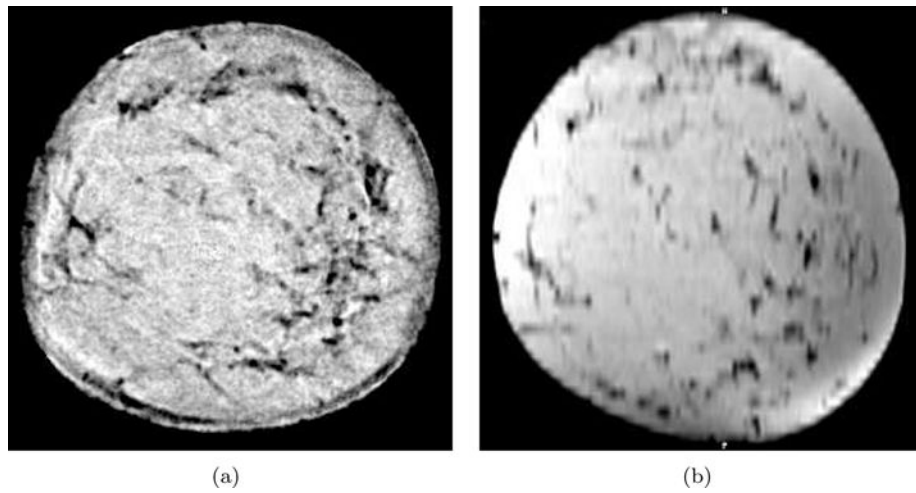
Comparison of waveform tomography reconstruction method using new ultrasound tomography unit to T1 weighted MRI. Gray scale values in the sound speed image have been inverted to match the gray scale convention of T1 MRI. The gray scale corresponds to a range of 1575–1400 m/s. (a) Waveform tomography sound speed reconstruction. (b) T1 weighted MRI.
